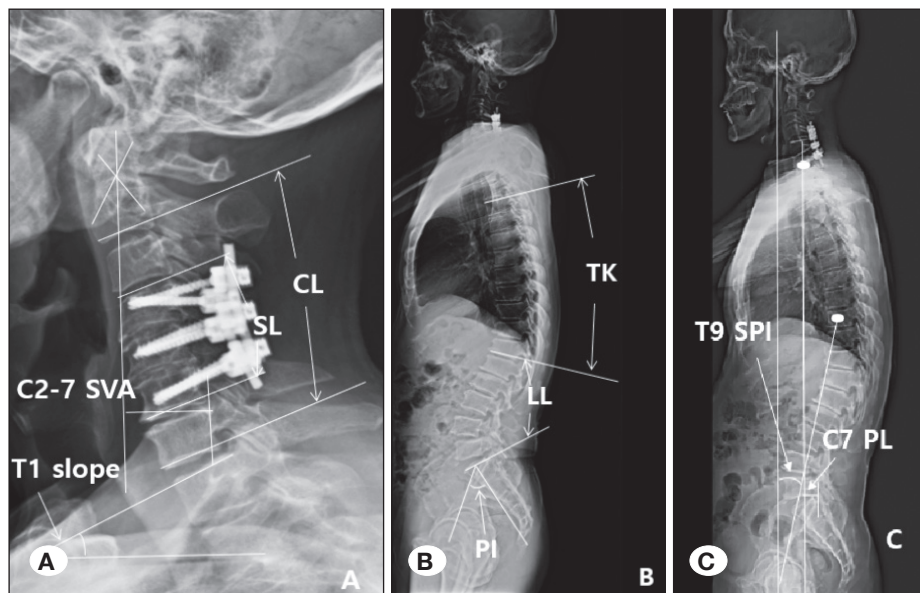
Measurement of cervical (A) and thoracolumbar parameters (B) and global spine alignment (C) on standard lateral cervical and whole spine radiographs. CL, C2 to C7 cervical lordosis (C2–C7); SL, segment lordosis; SVA, sagittal vertical axis; TK, thoracic kyphosis; LL, lumbar lordosis; PI, pelvic incidence; SPI, spinopelvic inclination.
